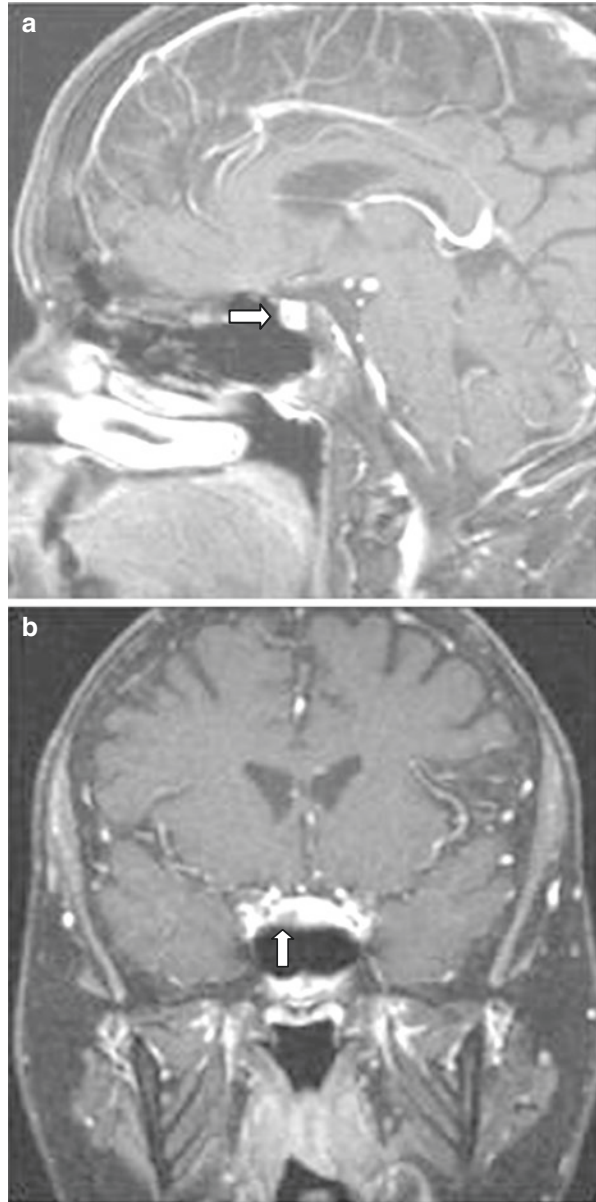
Pituitary MRI scan, sagittal (a) and coronal (b) view
